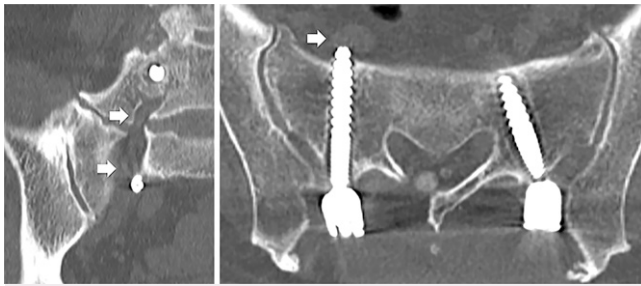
CT scans after right L5 rootgraphy. Left: Coronal CT image showing lateral compression of the right L5 nerve root (arrows) by the outwardly malpositioned S1 pedicle screw. Right: Axial CT image showing contact of the right L5 nerve root (arrow) with the perforating S1 pedicle screw and the radiolucent area of bilateral S1 pedicle screws, which indicates screw loosening.
